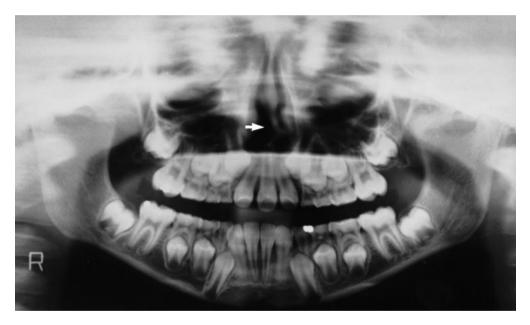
Orthopantomogram from a child aged 11 years (case 3). Note the symmetrical single maxillary central incisor and the asymmetric septum deviated to the left (arrow).
